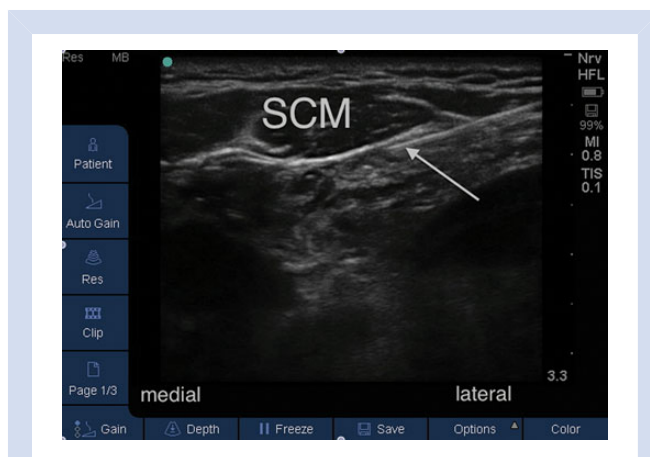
In-plane, longitudinal, ultrasound view with the arrow demonstrating the regional block needle advancing towards the superficial cervical plexus block underneath the lateral border of the sternocleidomastoid (SCM).
